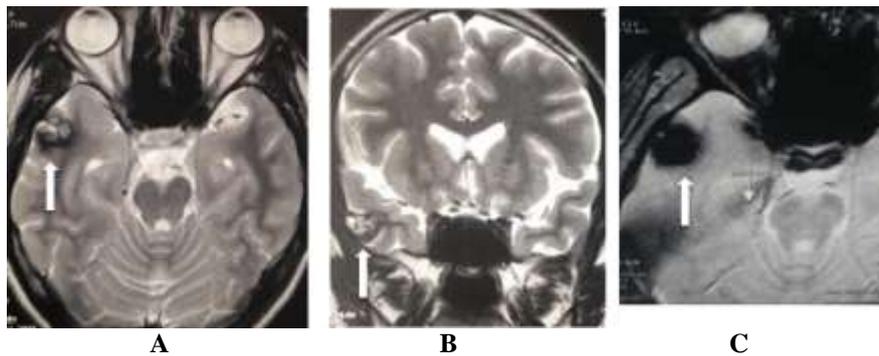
(A-C) Cerebral cavernous malformation in a 18 year female. MRI showing a cavernoma in the right middle temporal gyrus appearing heterogenously hyperintense on T2 weighted (A &B) images with a hypointense rim, evidence of blooming on GRE (C).
